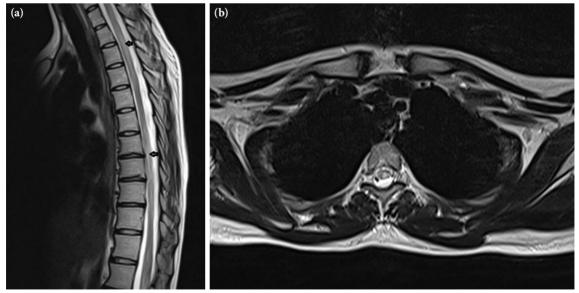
(a) Thoracic contrast-enhanced T2-weighted MRI showing a hyperintense lesion in the sagittal plane. (b) Patchy appearance in the medulla spinalis in the axial section on thoracic noncontrast-enhanced T2-weighted MRI.
